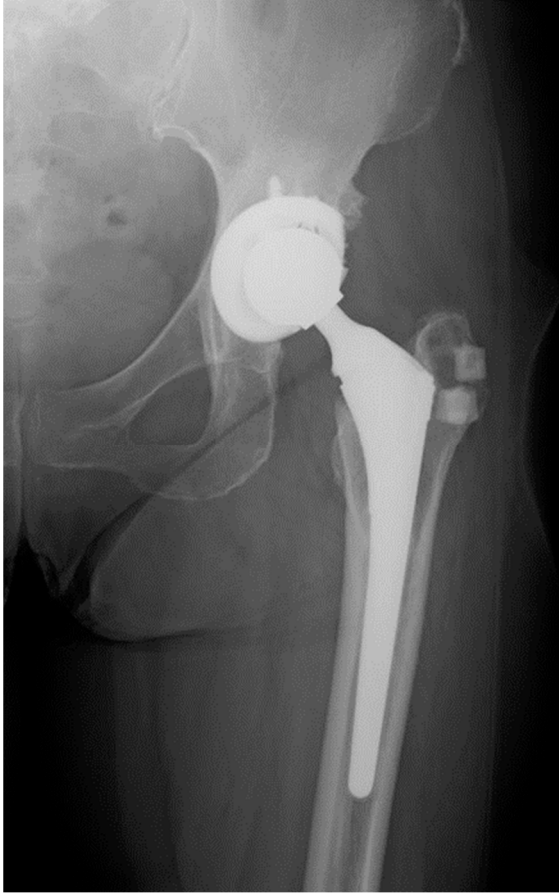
Radiographs of the left hip of a 63-year-old woman.
